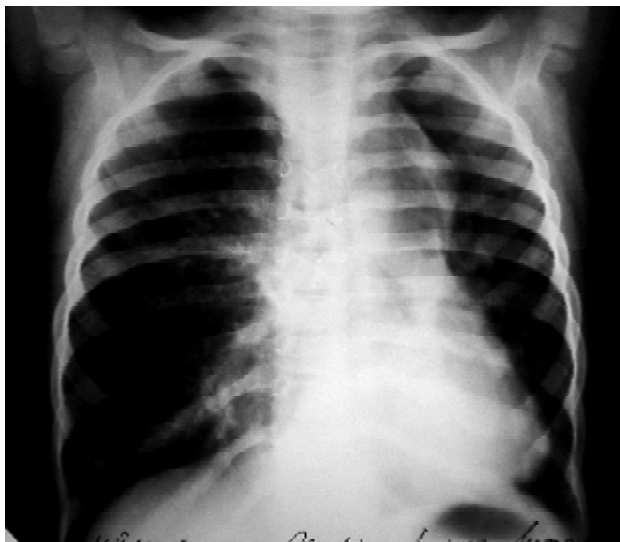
Straight X-ray film of chest after operation
